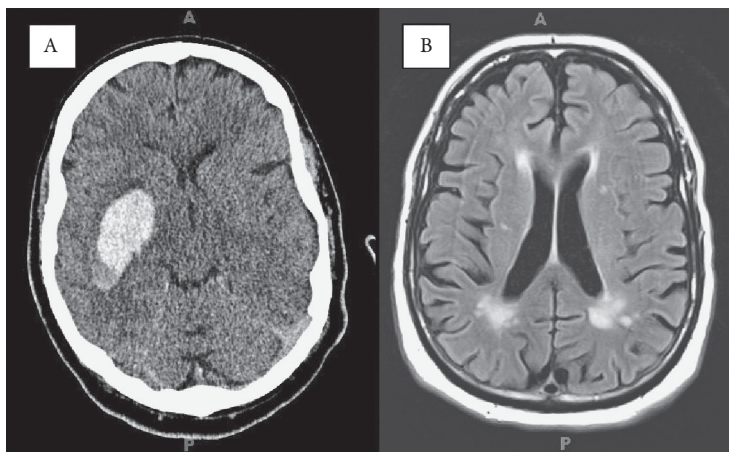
(A). Head computed tomographic scan showing right intracranial hemorrhage originating in the basal ganglia and extending into the temporal lobe. (B) Magnetic resonance imaging fluid-attenuated inversion recovery sequence demonstrating white matter changes surrounding the lateral ventricles and corona radiata as evidence of small vessel disease, or leukoaraiosis.
